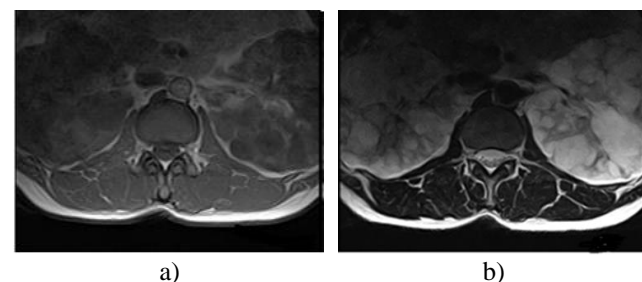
Axial T1-weighted image. a), and Axial T2-weighted image, b), showing innumerable cysts with grossly enlarged kidneys (ADPCK).
